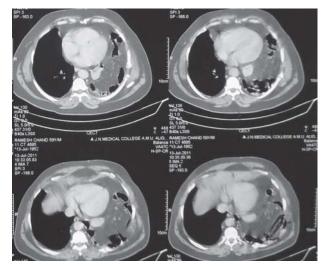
Contrast enhanced computed tomography of the thorax and abdomen showing a combined diaphragmatic and inter-muscular parietal thoracic and abdominal wall hernia.
